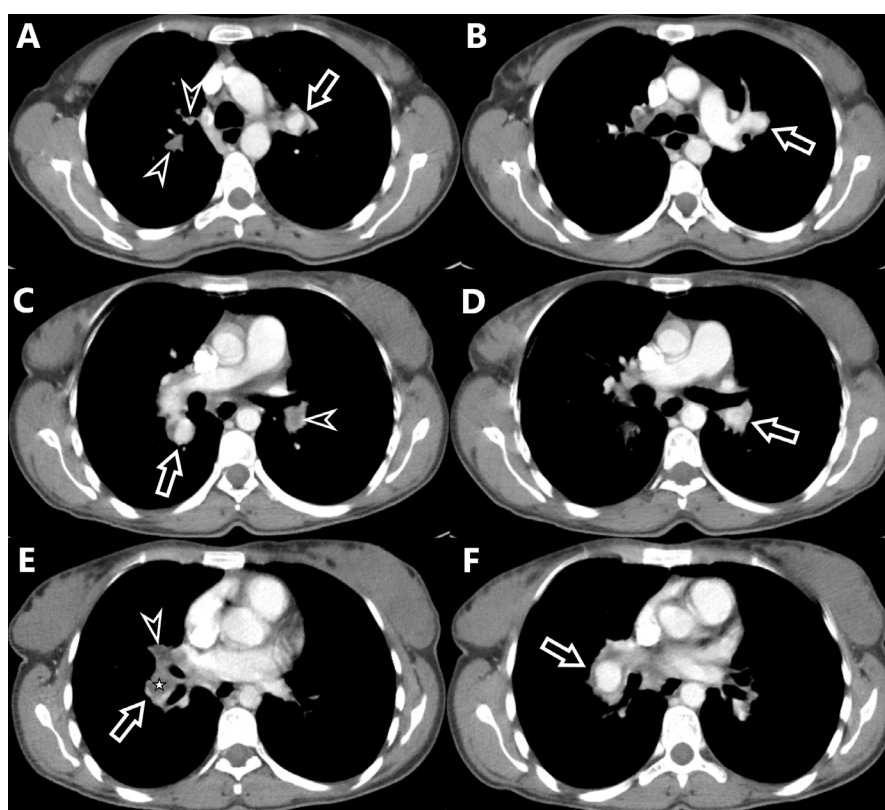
In a 34-year-old female patient diagnosed with Behçet's disease, a total of 6 peripheral pulmonary aneurysms (arrows), two in the upper lobe of the left lung (A,B), one in the left lower lobe (D), and three in the right lower lobe (C,E,F), are observed in contrast-enhanced thorax CT. Accompanying pulmonary embolisms (arrowheads) are seen in the pulmonary arteries in the upper lobe of the right lung (A) and the lower lobe of the left lung (C) and lower lobe of the right lung (E). In addition, a subtotal thrombus (star) is observed in the aneurysm lumen in the lower lobe of the right lung (E).
